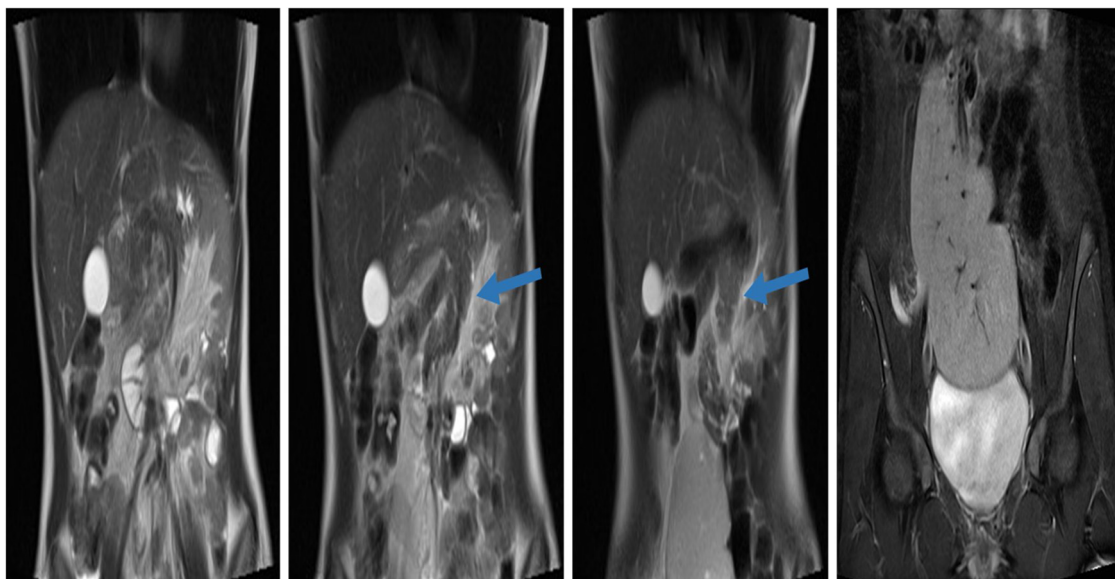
Coronal T2 and STIR sequences of MRI showing the pelvic spleen with the downward attracted pedicle and pancreatic tail (Blue Arrow).
